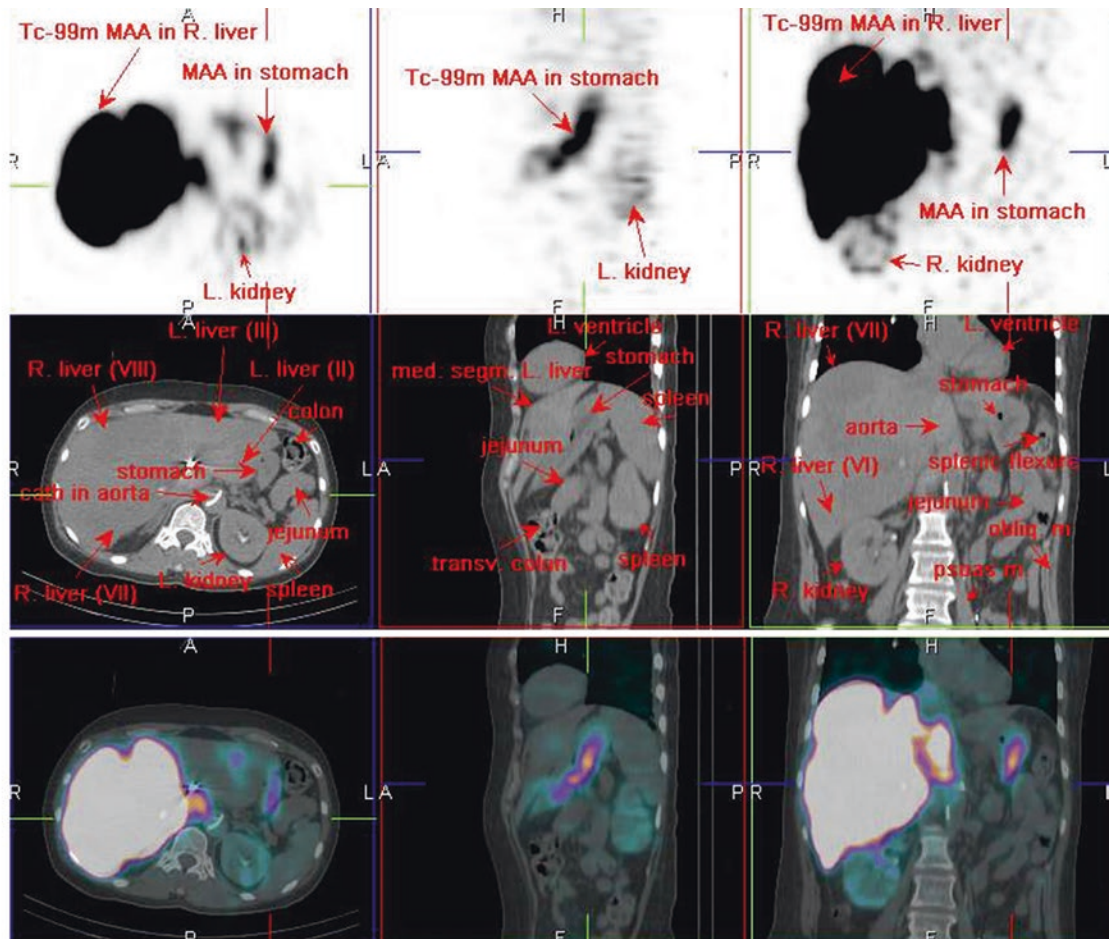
^{99m}Tc-MAA SPECT/CT
